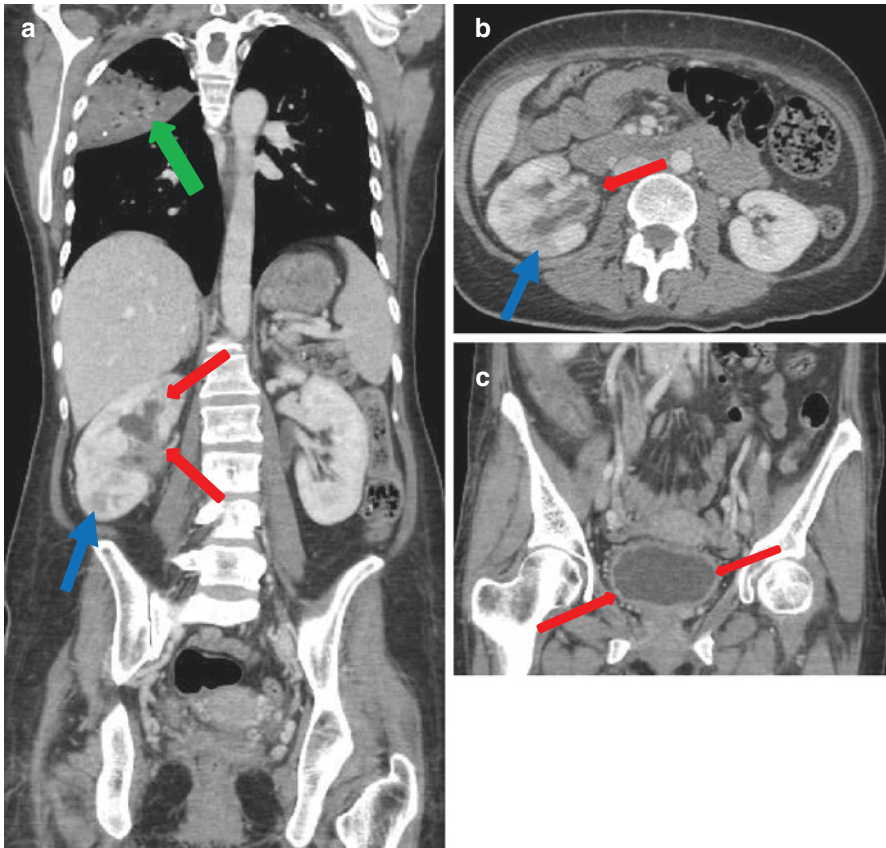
(a, b, c) Lung, renal and urothelial TB. Contrast enhanced Coronal Body CT (Image a) with axial CT (Image b) show urothelial thickening with associated upper pole calyceal dilatation (red arrows image a & b) due to structuring of upper pole infundibulum. Associated renal right lower pole patchy cortical enhancement (blue arrows a & b). Associated bladder wall thickening and inflammation (Image c coronal pelvic CT, red arrows). Constellation of features in keeping with urothelial and renal cortical TB. Associated lung consolidation right upper lobe (green arrow image a) *Image courtesy Dr Uday Patel, Consultant Radiologist, St George's Hospital NHS Trust, London, UK*
